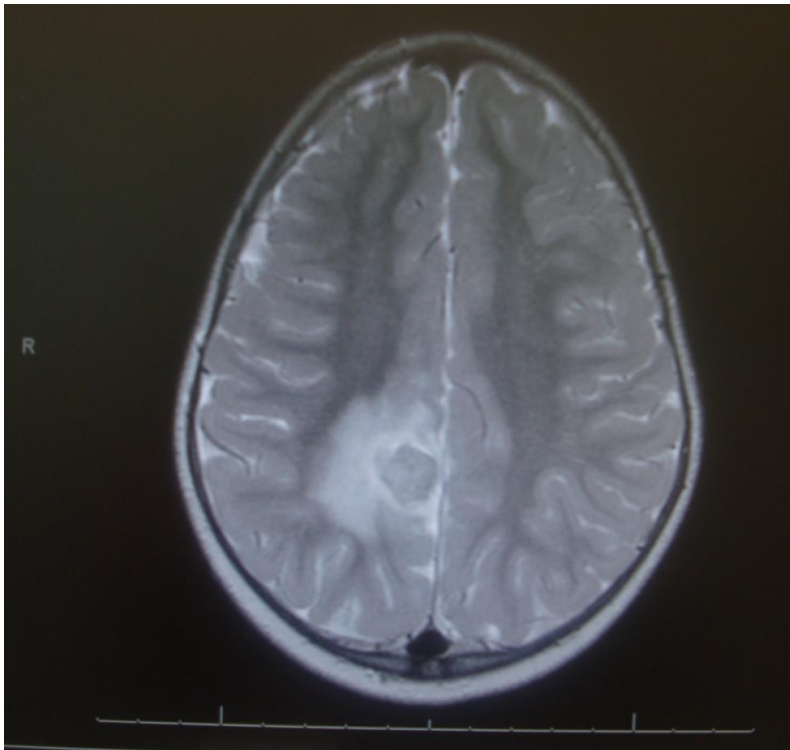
Tuberculoma. Magnetic Resonance Imaging showing rim-enhanced granulomas in the right para-falcine region posteriorly. The centre of the lesion is hypodense. Note the surrounding vasogenic oedema.
